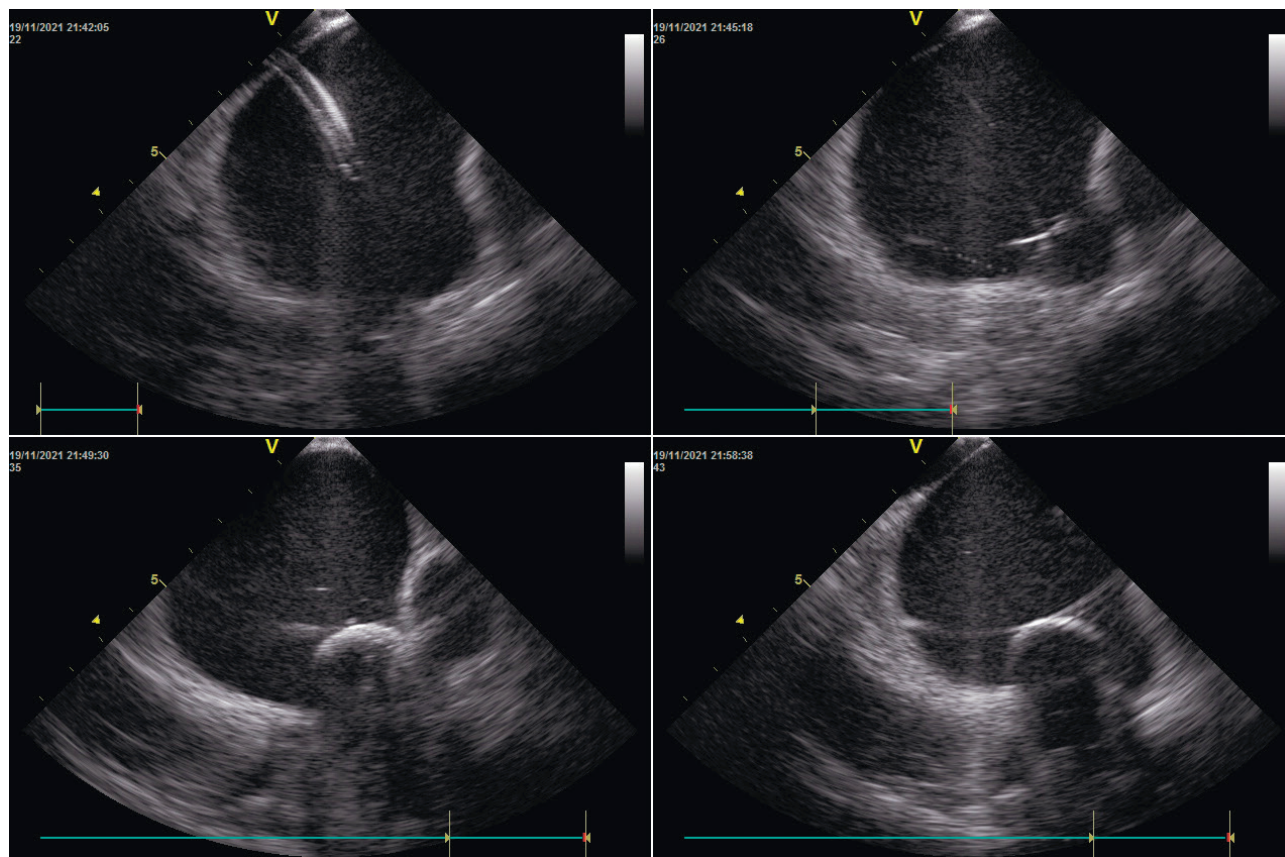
Cryoballoon positioning technique in the pulmonary vein orifices under control of intracardiac echocardiography.
